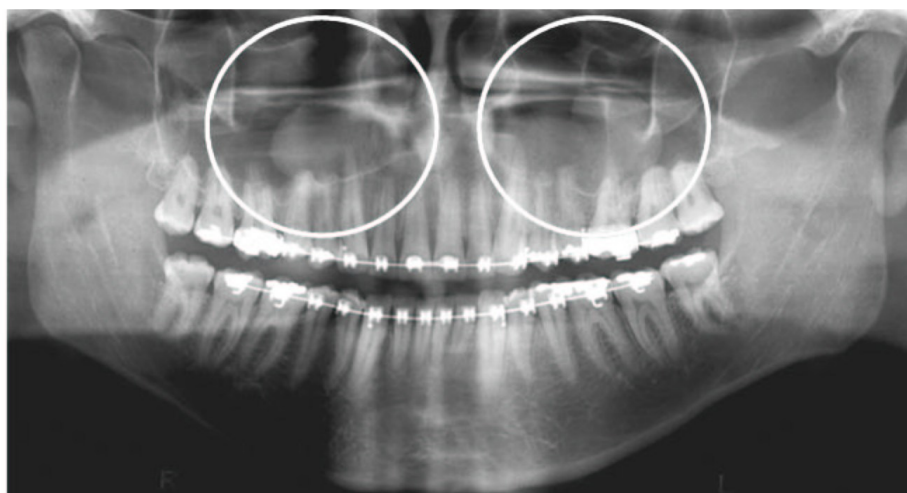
Panoramic radiograph of a 32-year-old male patient. Image suggestive of bilateral mucous retention cyst (circles)
